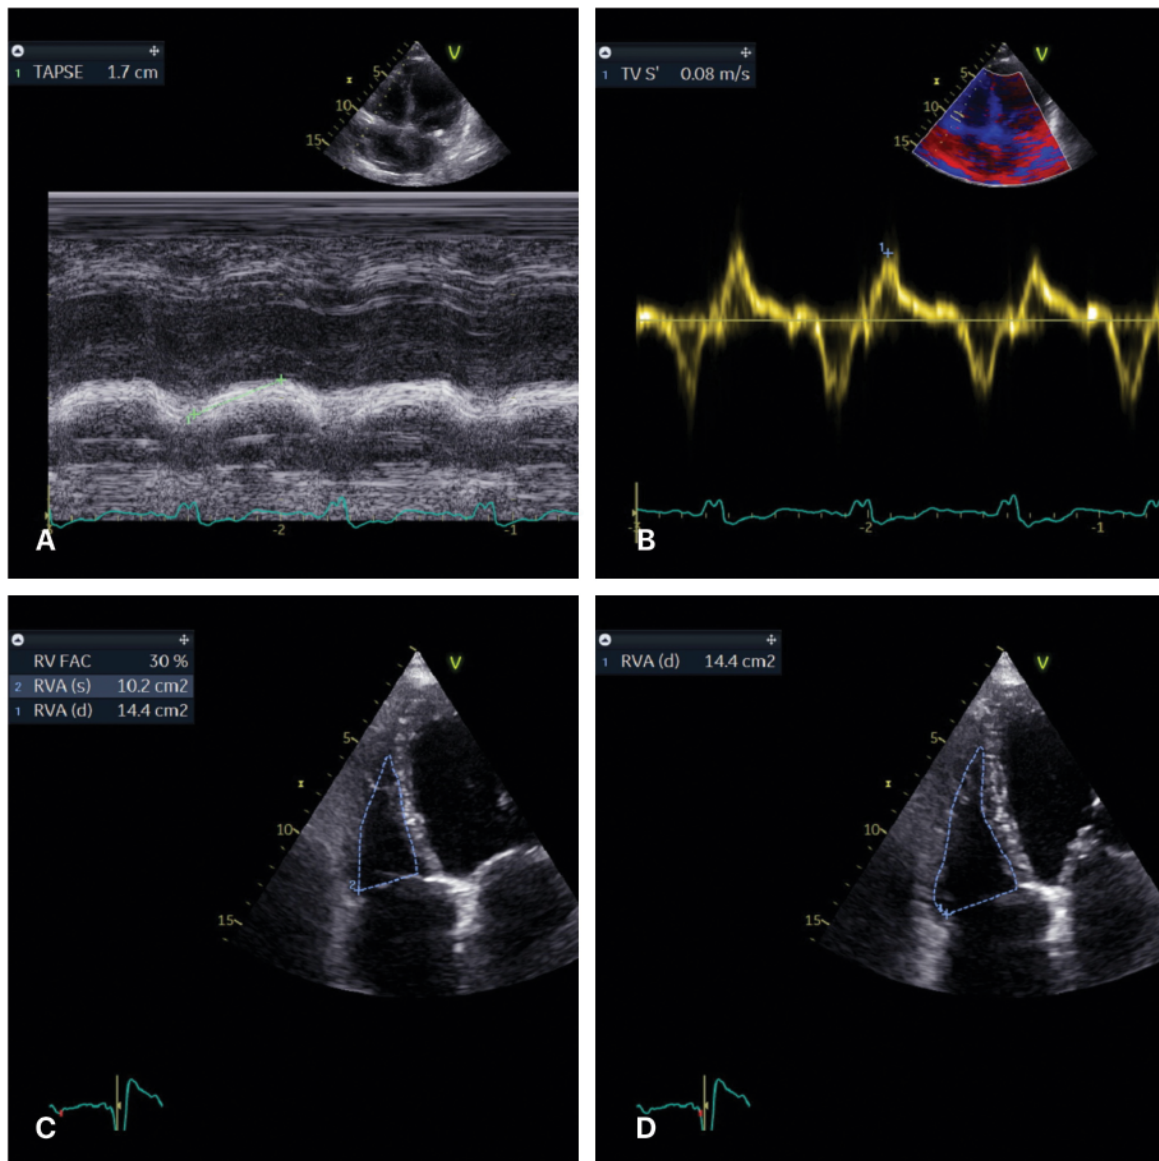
Parameters of RV systolic function. A: Tricuspid annular systolic excursion (TAPSE) measurement. B: Tricuspid S' systolic velocity using tissue doppler imaging. C,D: calculation of RV fractional area change (RV FAC) tracing RV area in systole (C) and diastole (D).
